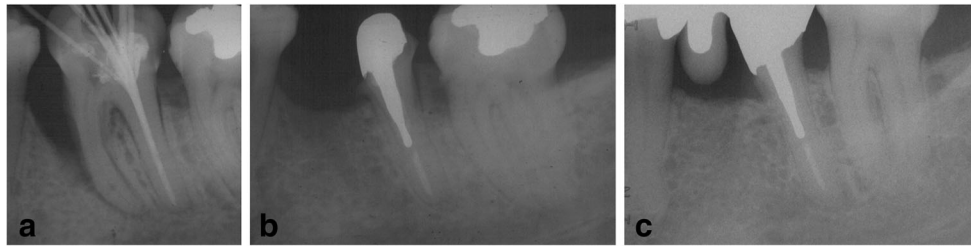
Example for the treatment sequence. Tooth 36 with deep infrabony defect at the mesial aspect and furcation involvement due to periodontitis, root canal treatment of the distal root (a, 27.01.1983). Radiographic control after resection of the mesial root and insertion of a
